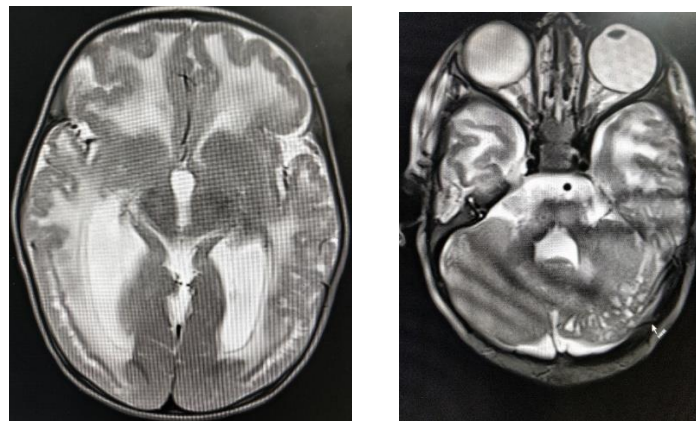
Axial T2 weighted MRI Brain images through third and fourth ventricles respectively of an infant reveal pachygyria in bilateral frontal and occipital lobe, polymicrogyria in bilateral temporal lobes, unmyelinated periventricular white matter, a band of subcortical gray matter spanned by unmyelinated white matter, ventriculomegaly, absence of foliar pattern in cerebellar hemispheres and numerous small cysts in left cerebellar hemisphere.
